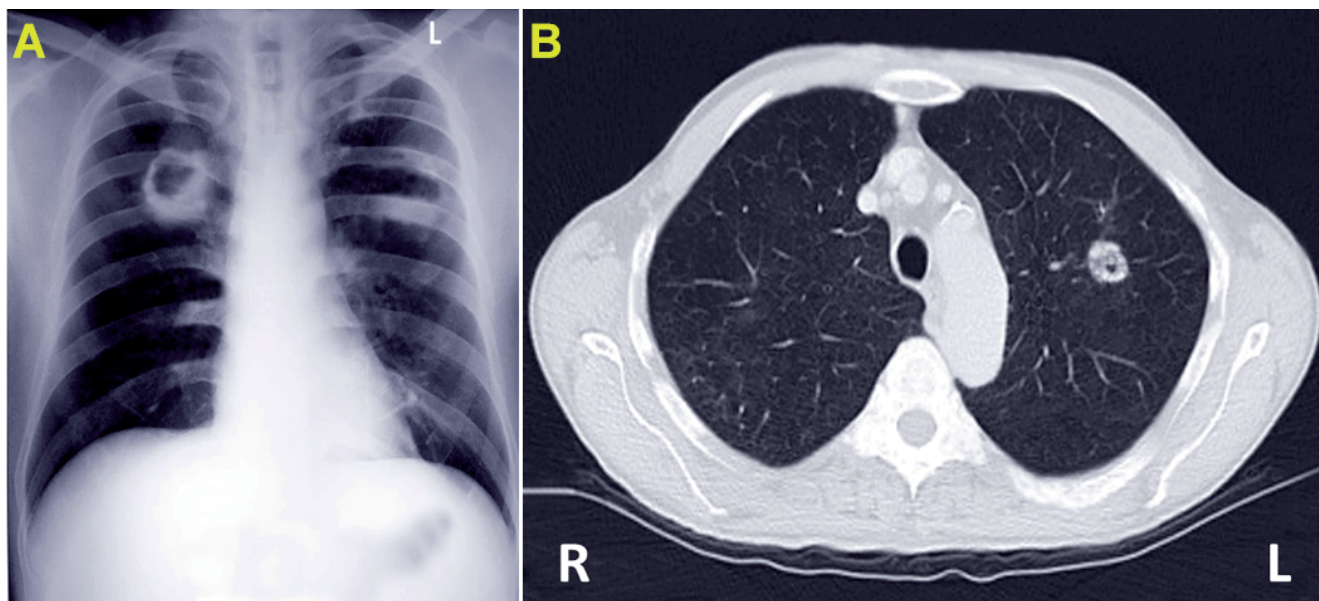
A) Chest x-ray showing a unilateral cavitory lesion in the right lung superior lobe. B) CT scan showing a unilaterally cavitory lesion in the left lung.
